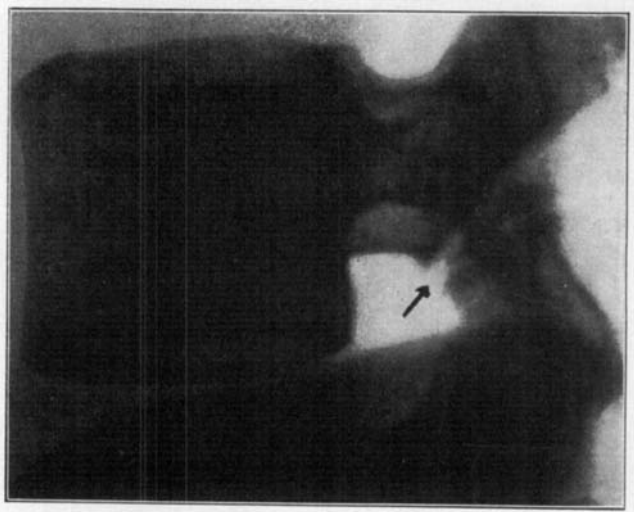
Roentgenogram showing details of fifth lumbar vertebra. Spondylolysis.
